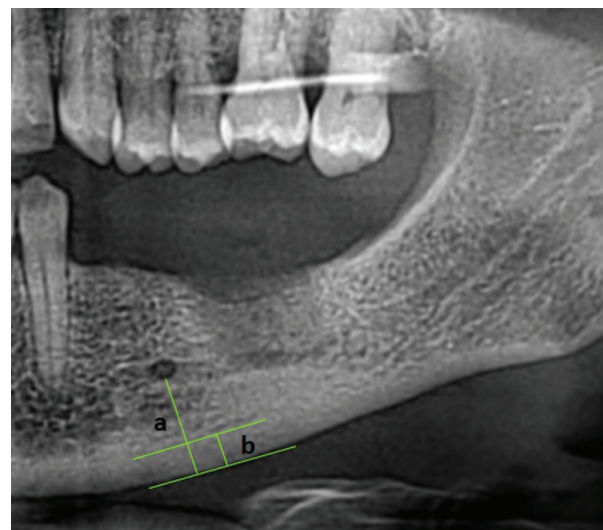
Measurements of PMI and MCW on panoramic radiography
